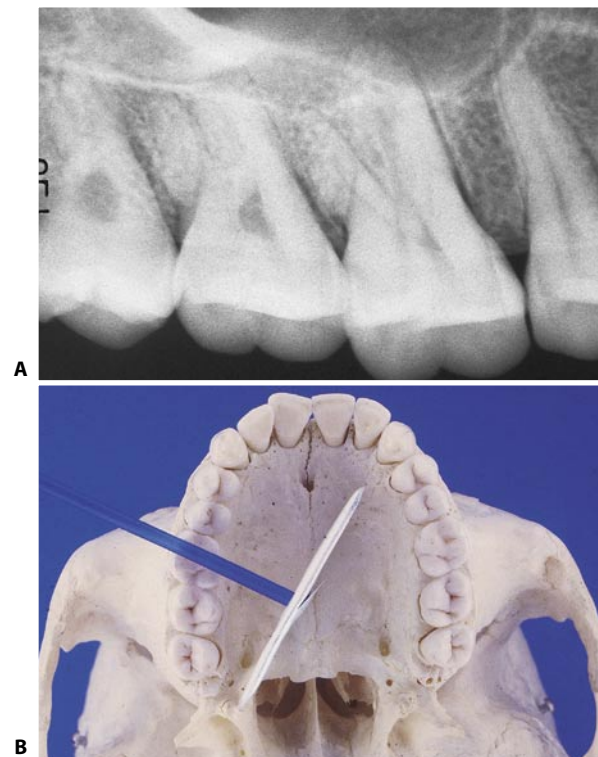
A. Angulation of the X-rays mesiodistally takes away the distobuccal root from the superimposition with the palatal root. B. Path of the X-rays in the mesiodistal projection.
